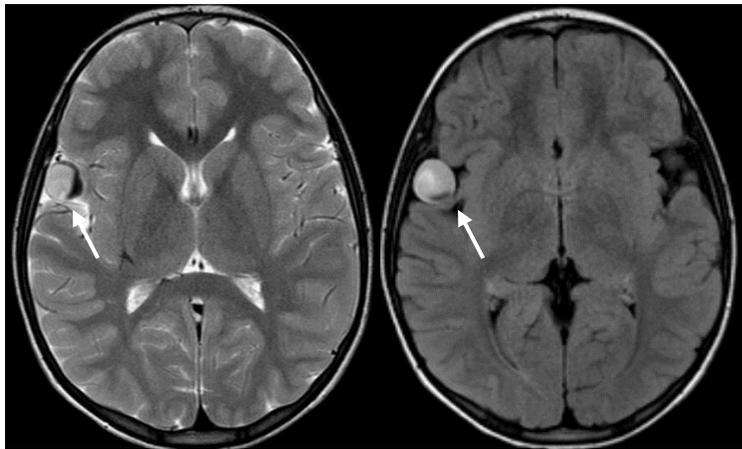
MRI in 2019, regression of the venous aneurysm is noted 17mm x 18mm.
